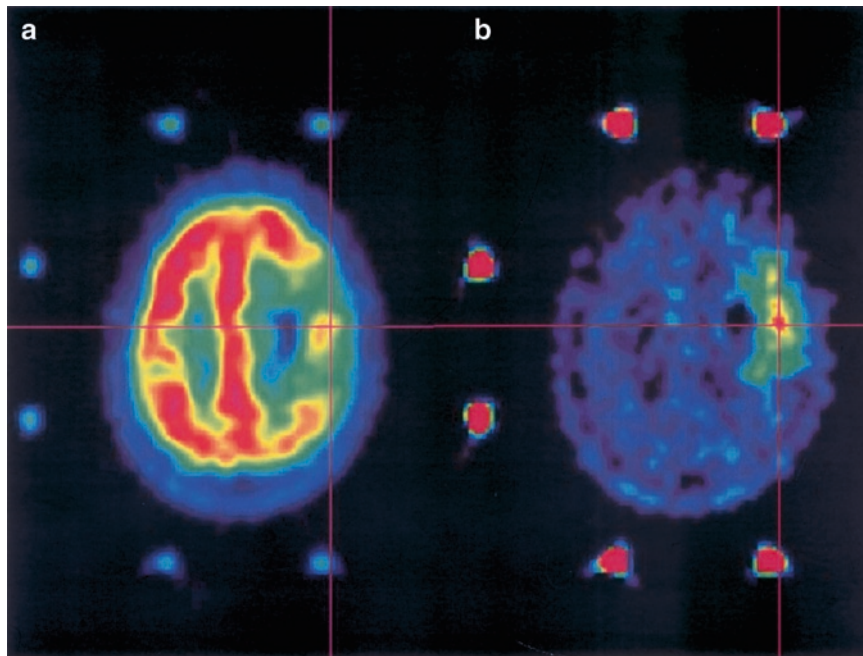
Stereotactic FDG-PET (a) and Met-PET (b) images in an anaplastic astrocytoma located in the right fronto-rolandic cortical area. Tumor FDG uptake was lower than that of the surrounding grey matter and a target could not be defined on FDG-PET. Therefore, Met-PET was used for target selection
